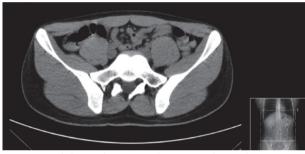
Abdominal computed tomography with an image compatible with Meckel diverticulum (marked by *) with thickening and enhancement of the wall of the diverticulum and densification of the surrounding fat.
